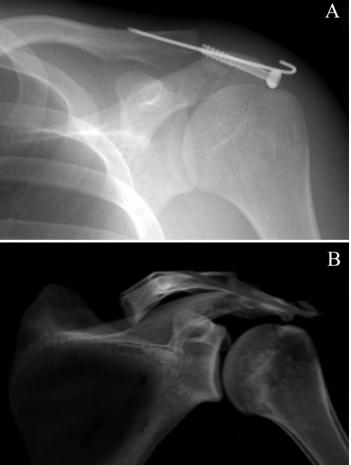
Post-operative imaging including (A) plain radiograph and (B) 3D CT reconstruction after arthroscopic reduction and internal fixation of acromion fracture.
